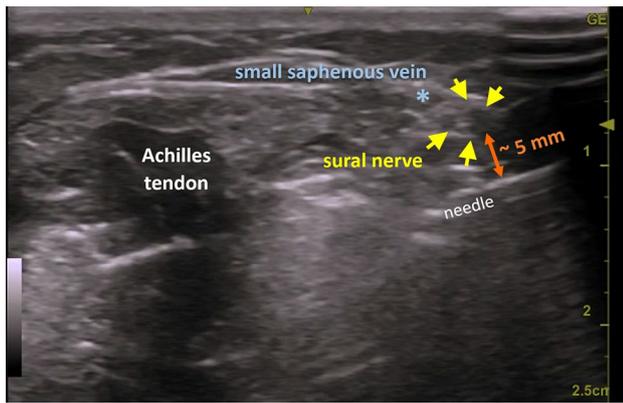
Sonographic image showing the passing of the needle from the lateral side (right) of the Achilles tendon going medial (left). In this case, the distance of the needle from the sural nerve (yellow arrows) is approximately 5 mm. The small saphenous vein (blue asterisk) is superficial and medial to the sural nerve and serves as a useful landmark to aid in the visualization of the sural nerve
